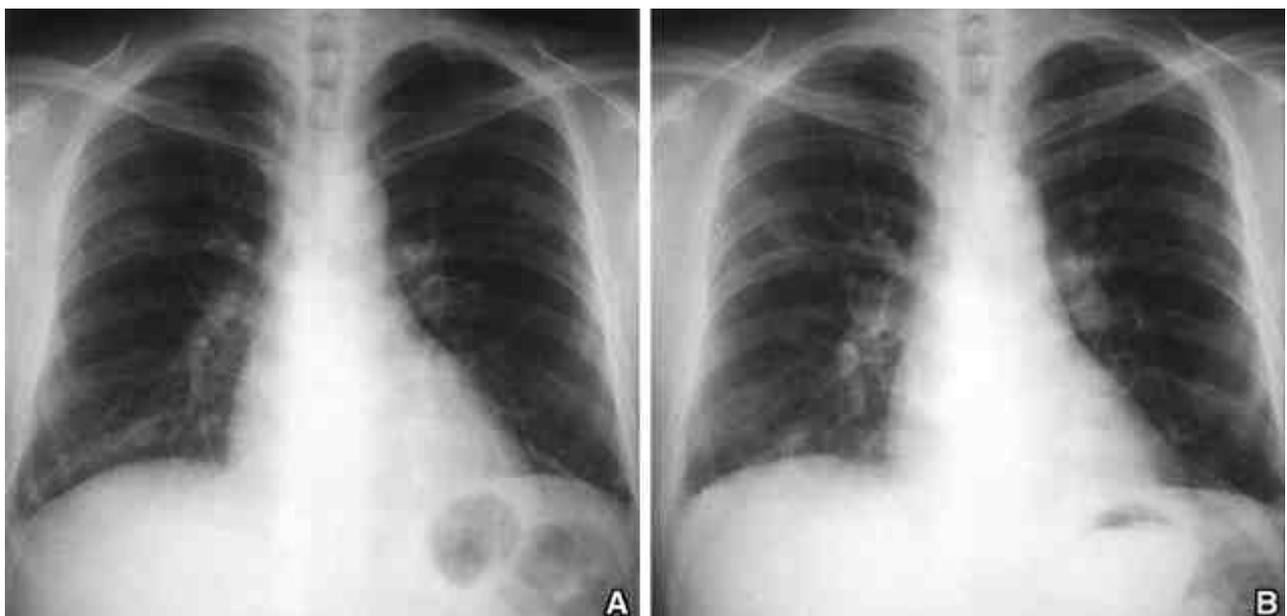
A: Chest radiograph shows bilateral pleural thickening and a small effusion with increased interstitial markings on the adjacent lung. B: Follow-up chest radiograph shows progressive interstitial fibrosis on both the lower lung fields as compared to the admission day.
